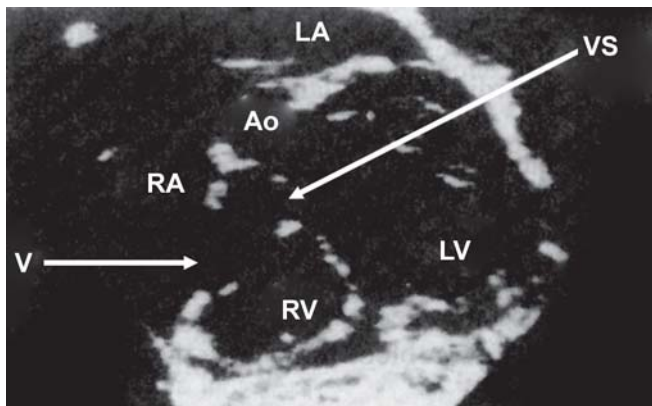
Echocardiography (subcostal four-chamber view) of a ventricular septal defect (VSD)
